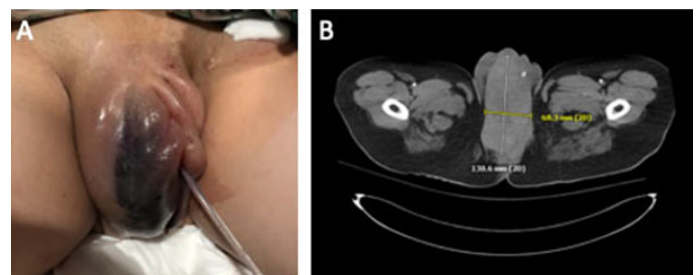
Rapidly expanding puerperal hematoma. (A) Clinical photograph of right labial hematoma with Foley catheter in place. (B) Transverse section CT of the pelvis confirms large vulvovaginal hematoma.
